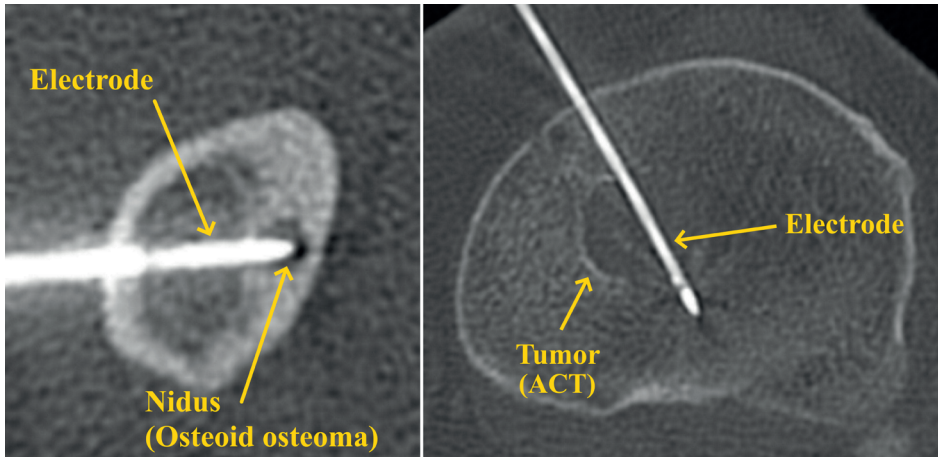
CT Images of two intra-operative images of an RFA procedure. Left, RFA of a small OO. Right, RFA of an ACT. In both cases, the tumors appear as lower density areas (with a darker color) compared to the surrounding bone whereas the electrodes appear as linear high-density structures traversing the tumors.
